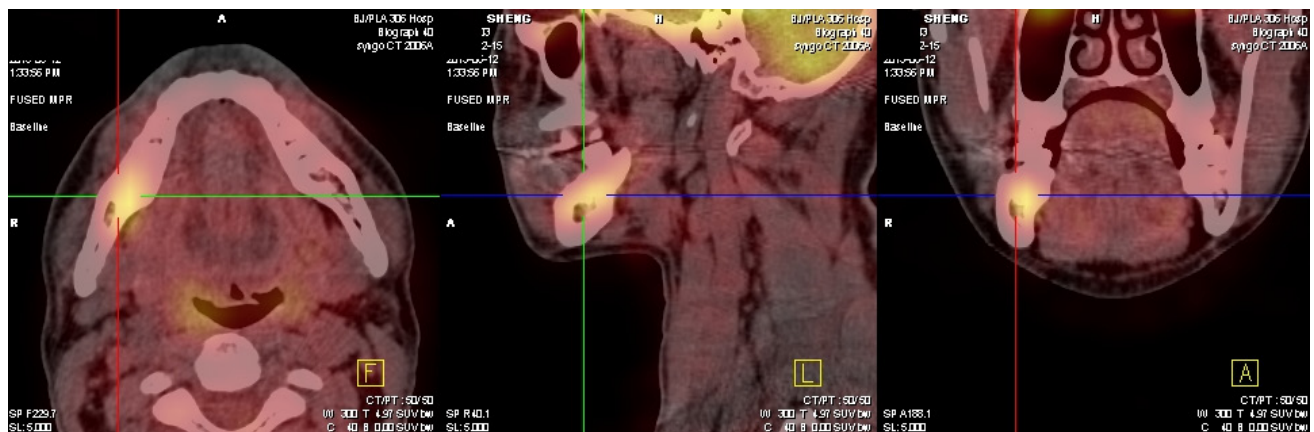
Male, age 55, lower right Gingival squamous cell carcinoma (cross-marked), SUVmax is 3.77, activity-range is 1.2 × 2.6 × 1.5 cm with no surrounding tissues invasion. SUVmax, maximum standardized uptake value.
